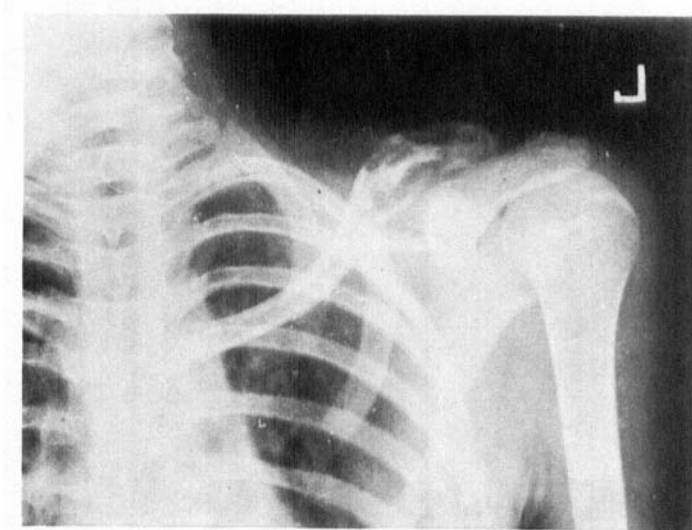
a. X-ray photograph showing expansion of the entire clavicle on the left side.*
